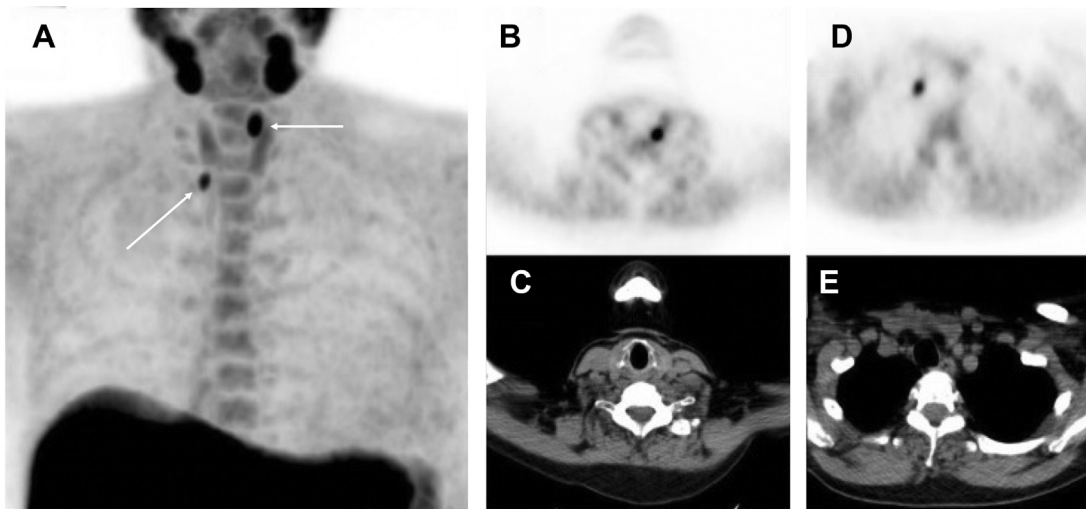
Patient with hypercalcemia and hyperparathyroidism underwent F-18-fluorocholine PET/CT scan showing a double parathyroid adenoma. (A) On a coronal PET image, 2 foci of intense choline uptake are noted in the neck (arrows), with physiologic uptake in the salivary glands, thyroid gland, liver, spleen, and marrow. Axial PET (B) and CT (C) images show foci of uptake posterior and superior to the left thyroid lobe measuring 7 × 5 mm and maximum standardized uptake value of 8.7. Axial PET (D) and CT (E) images show uptake inferior to the right thyroid lobe measuring 6 × 4 mm and maximum standardized uptake value of 5.6. (Courtesy of Dr. Wouter Broos.)
